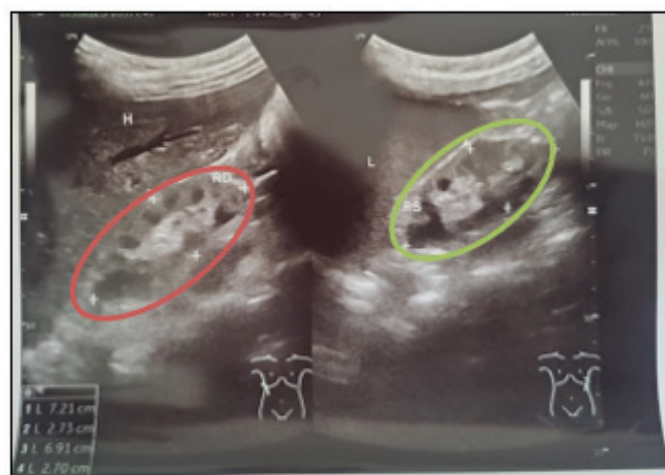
Abdominal ultrasound on 12 July 2025
